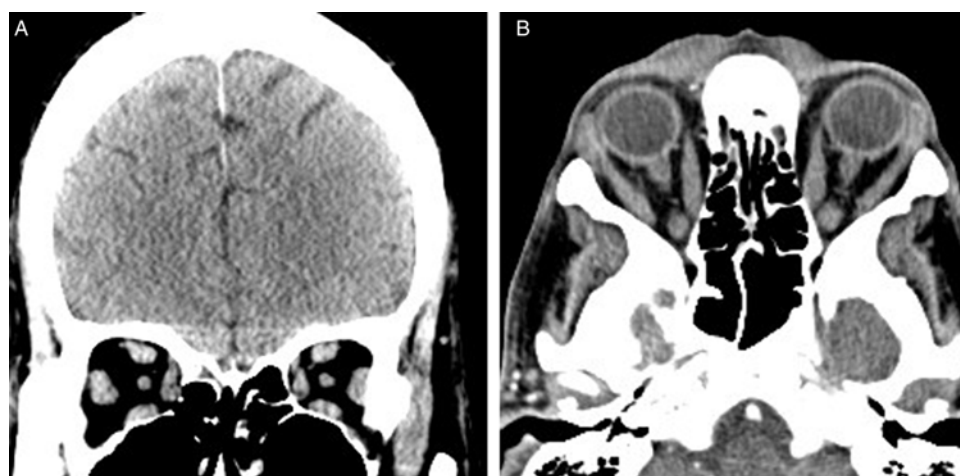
(A) CT brain, coronal sequence, demonstrating mild to moderate enlargement of all extraocular muscles. (B) CT brain, axial sequence, showing enlargement of extraocular muscles sparing the tendons.
